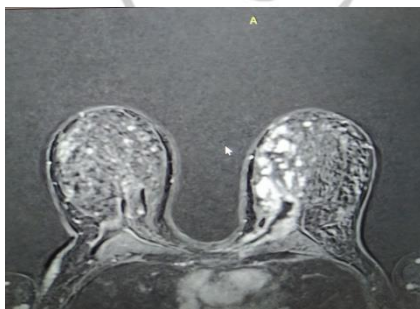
MRI shows NME lesion.
